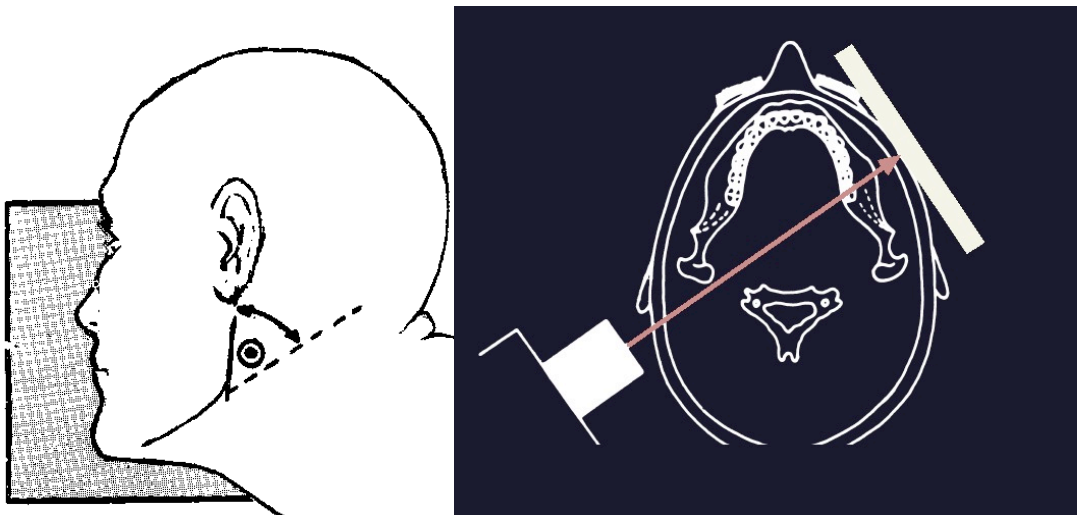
Lateral oblique radiographs technique.
